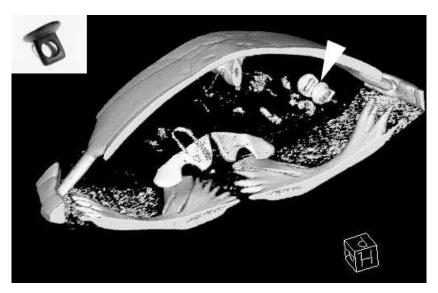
Three-dimensional maximum intensity projection slab reconstruction from the first computed tomography scan. The image shows the rubber objects in close proximity in the left cranial quadrant. The insert shows an image of one of the rubber suction cups taken after recovery.
